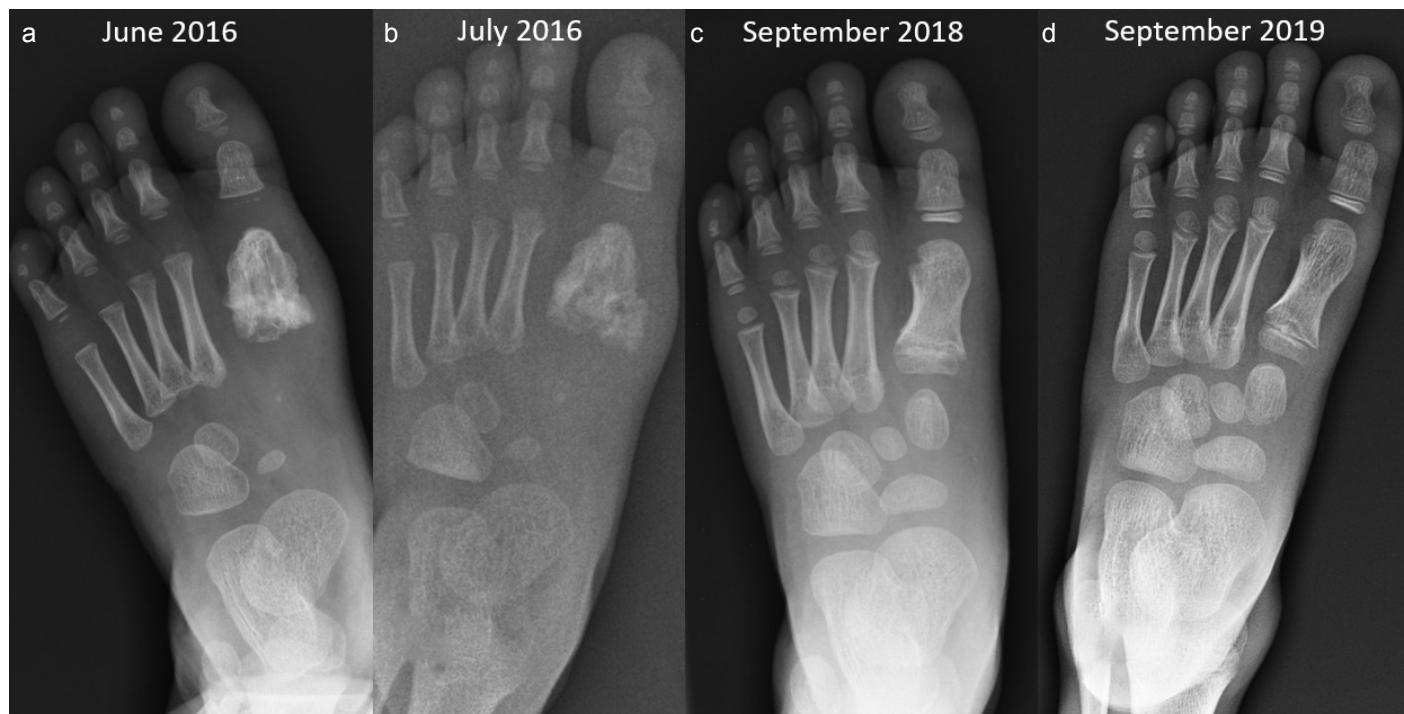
a-d. (A) X-ray of the foot at the first observation: a calcified mass adjacent to the cortical surface of the first metatarsal is detected. (B) X-ray of the foot performed 2 weeks after biopsy: a calcified and ossified mass is still evident around the first metatarsal. (C) After 2 years: the calcified mass has disappeared and the first metatarsal bone assumes a more physiological morphology. (D) After 3 years: no local recurrences of Nora's lesion are evident and the first metatarsal shows a completely normal structure
